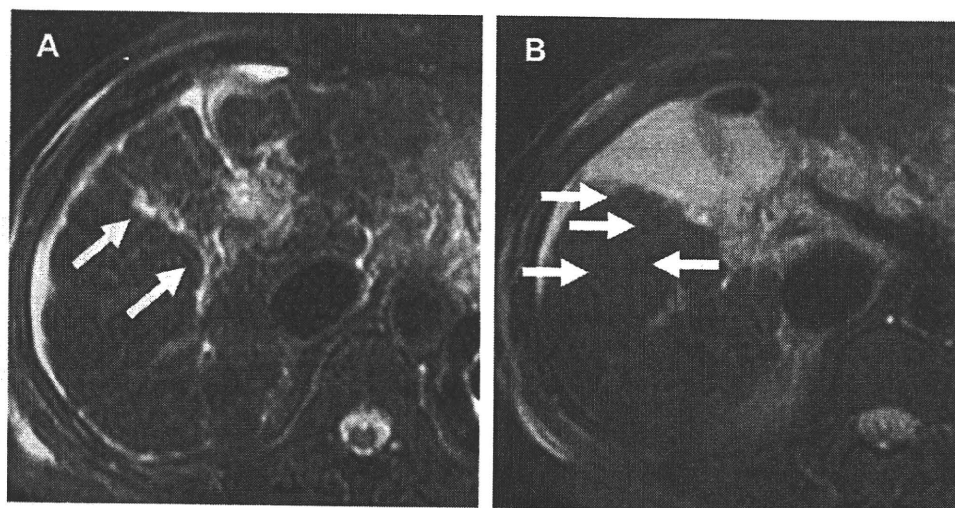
T2-weighted fat-saturated TSE image in a patient with primary biliary cirrhosis shows periportal hyperintensity (A) (arrows) around portal tracts and areas of low-intensity signal (B) (arrows) encircling the portal veins, presenting the periportal halo sign.
